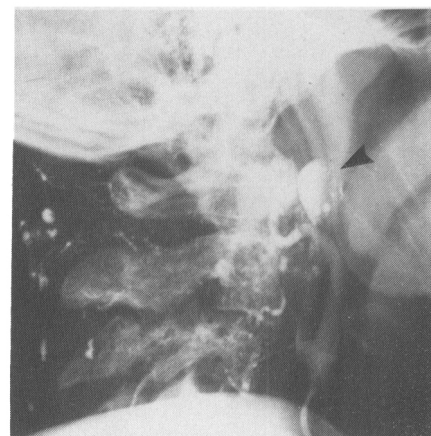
Post embolization plain film. The plain film following embolization shows the distribution of the pantopaque labelled Gelfoam. Note the large collection in the ascending pharyngeal aneurysm (arrowhead).
